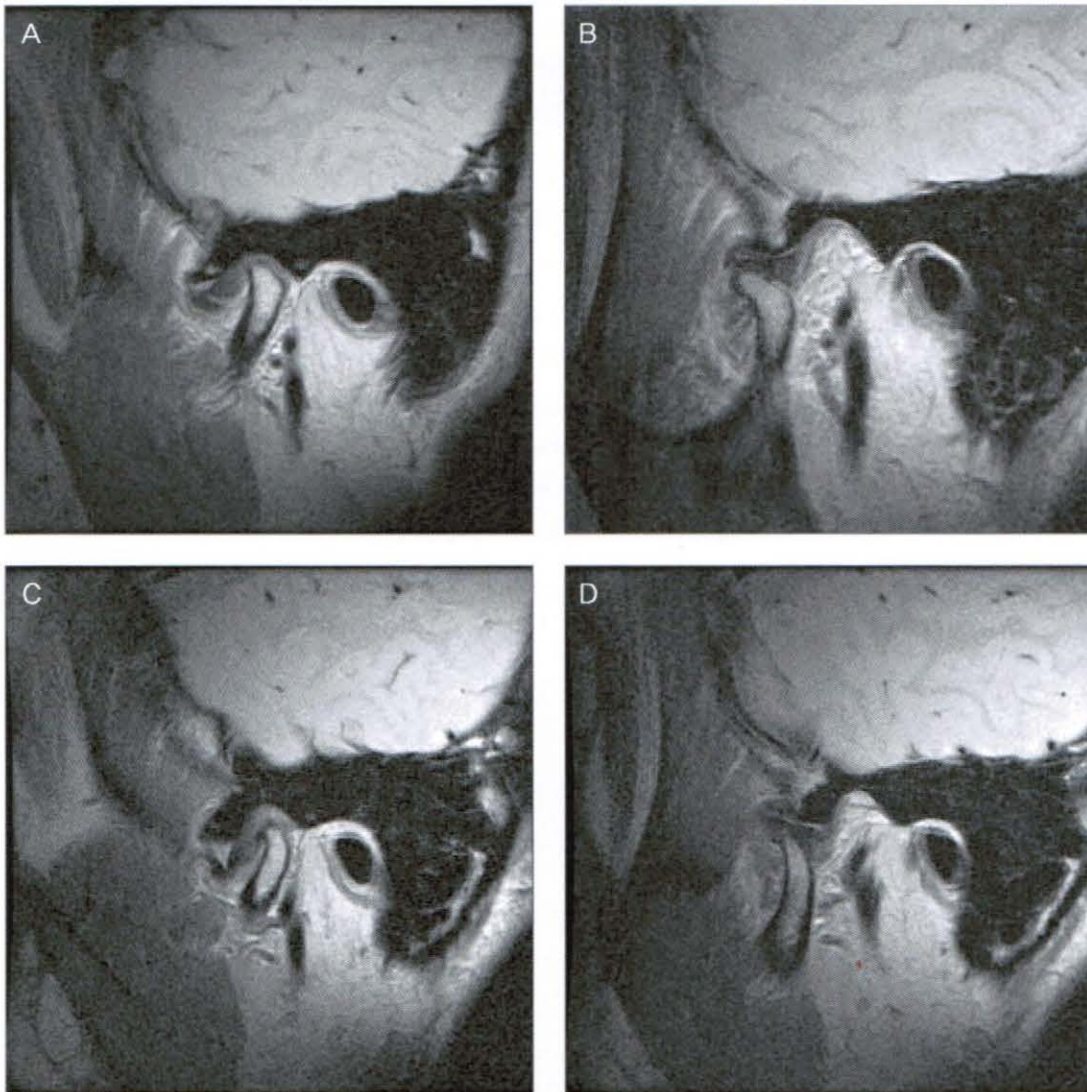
Pre-treatment TMJ MRI (2006, 11,13)
